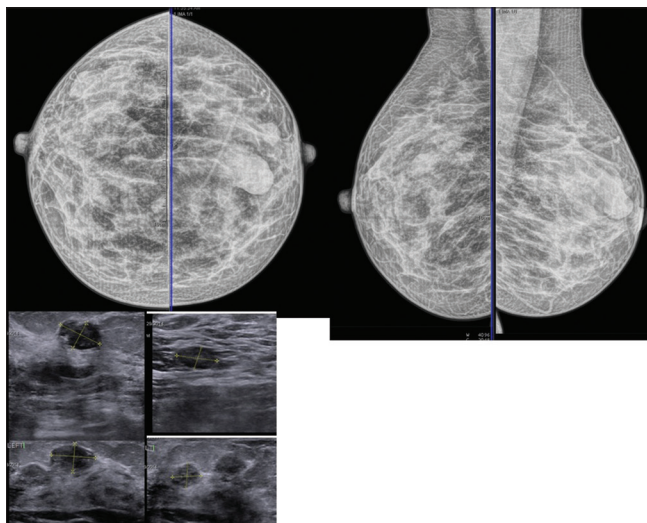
Mammography two well-defined radioopacities in left breast. Sonography showed sols in both breast, likely to be benign, presumed fibroadenomas
